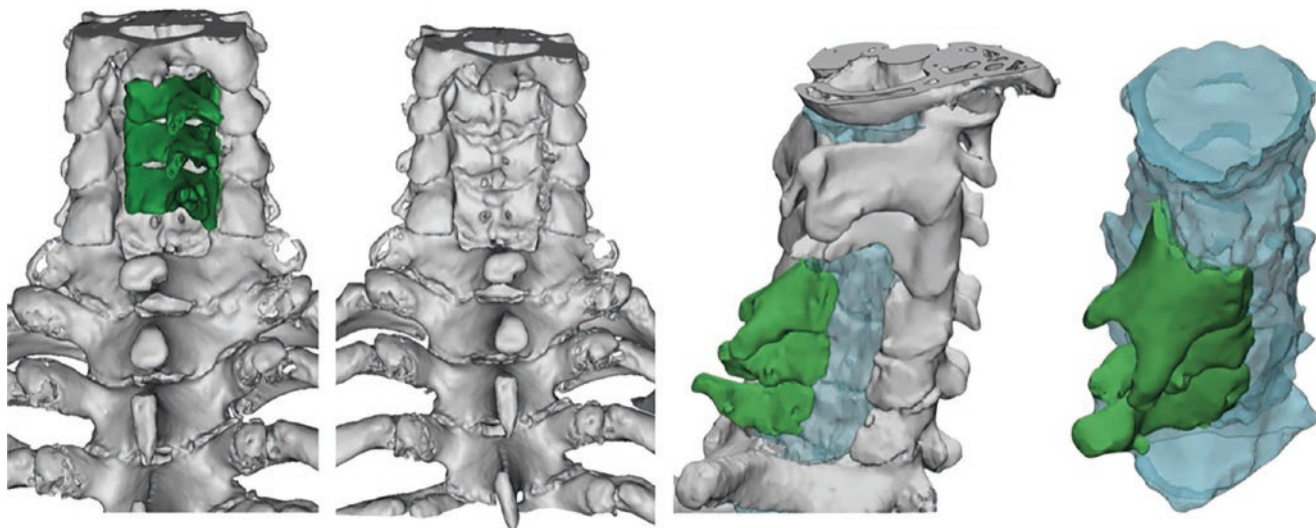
Anatomical models after open-door laminoplasty from postoperative CT; isolation and removal of rotated laminae is shown in green; laminae are then hidden to uncover the expanded intradural space, reconstructed in blue
